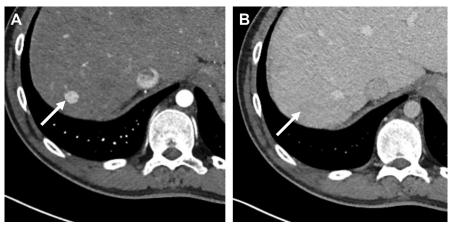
A 26-year-old boy with history of Fontan procedure as a child for transposition of the great arteries. Axial contrast-enhanced CT (*A*) obtained during hepatic arterial phase shows an avidly enhancing lesion in segment 7 (*arrow*). No convincing associated washout or "capsule" is seen during venous phase (*B*). The lesion remained stable for at least 3 years suggestive of an FNH-like nodule.
